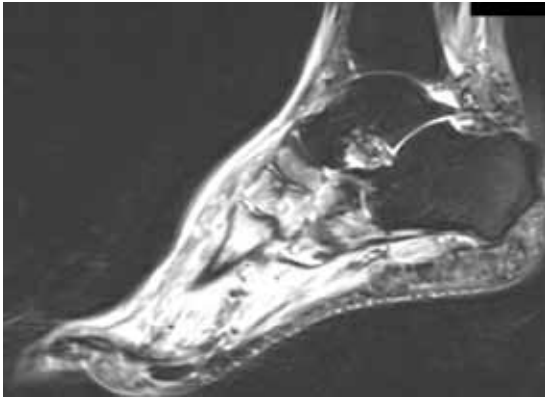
Magnetic resonance imaging 4 to 6 weeks after presentation shows areas of significant bone marrow edema of the navicular, medial, middle, and lateral cuneiform bones, and at the bases of several metatarsal bones.
